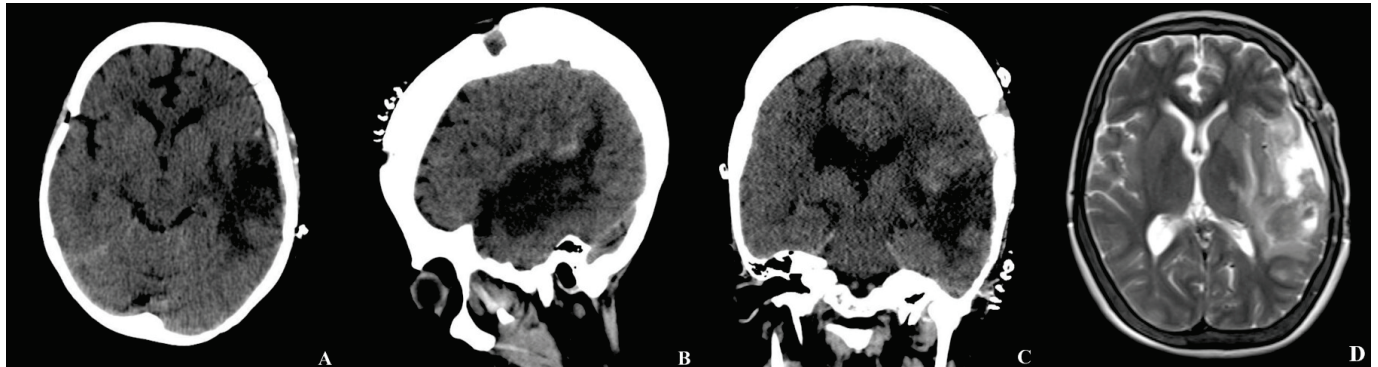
Brain CT and MRI obtained on the seventh postoperative day ((A) axial, (B) sagittal, (C) coronal view, (D) axial T2-weighted image). The postoperative CT demonstrates resolution of the previously observed midline shift and a marked decrease in perilesional cerebral edema. No new hemorrhage or ischemic changes are evident. The corresponding MRI sequences confirm a reduction in the mass effect, an improvement in ventricular compression, and postoperative changes consistent with hematoma evacuation.
